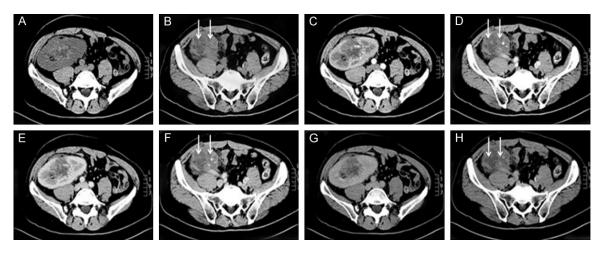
Abdominal multislice CT scan by triple phase enhancement reveals patchy inhomogeneous enhancement, 7.0 × 7.8 cm in size, in the upper course of the pelvis and ureter. The lesions surround the blood vessels in the renal sinus, the pelvis and the ureter. A and B: Plain CT scan; C and D: The cortex phase; E and F: The parenchyma phase; G and H: The excretion phase.
